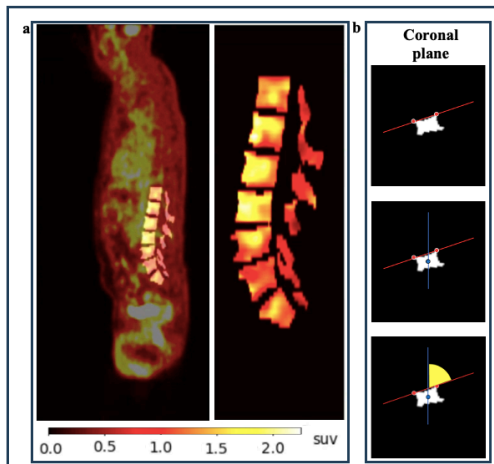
(a) SUV maps of vertebrae from T12 to S1. (b) Steps followed to obtain the vertebral inclination angle (central coronal slice)
